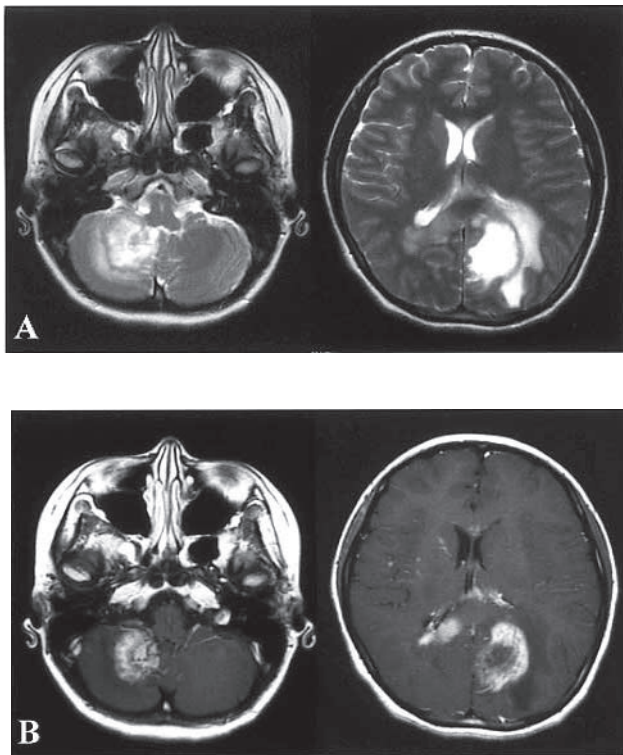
T2-weighted (A) and contrast-enhanced T1-weighted (B) MR images show a large enhanced lesion with surrounding edema and mass effect in the right cerebellum, a large ring-enhanced lesion with surrounding edema and mass effect with central necrosis in the left occipital lobe, as well as multiple enhancements in the corpus callosum.
